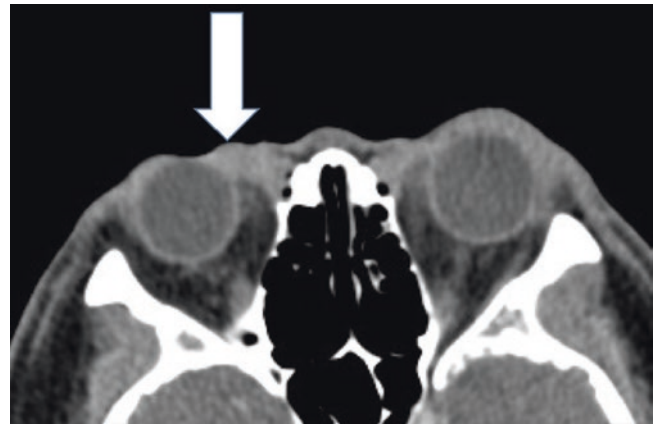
Axial CT scan showing a diffuse bilateral preseptal mass involving the lacrimal sac fossa area (arrow showing the right sided mass) with mild enhancement with contrast
